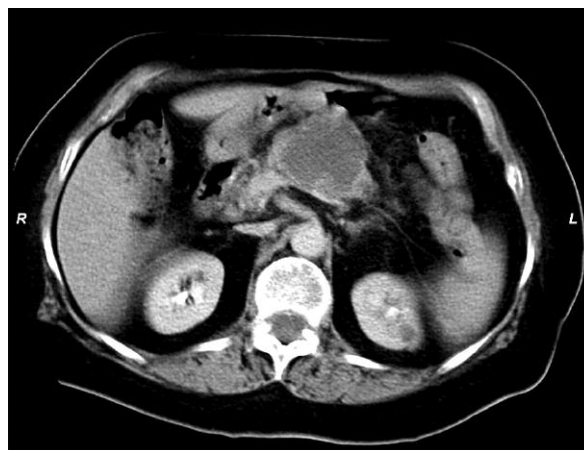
Huge tumor of the body of the pancreas. Computed tomography scan shows possible neoplastic infiltration of the stomach wall
